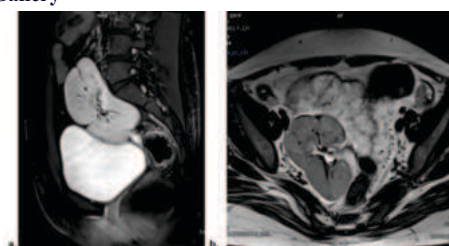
T1w post contrast sagittal (a) and axial (b) MRI sequence demonstrates an ectopic right kidney associated with MRKH
